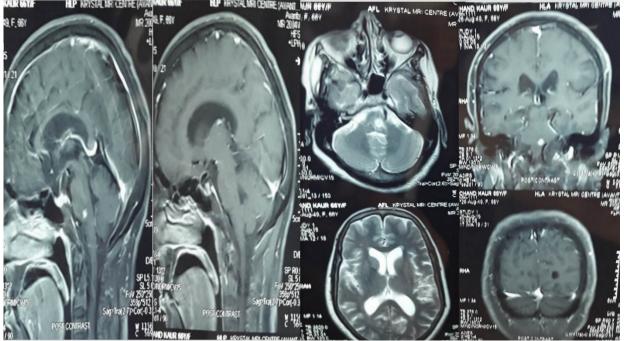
MRI brain of the patient revealing an approximately 5mm enhancing nodular lesion on the left side of pons near ponto-medullary junction with perilesional edema extending into pons and medulla
